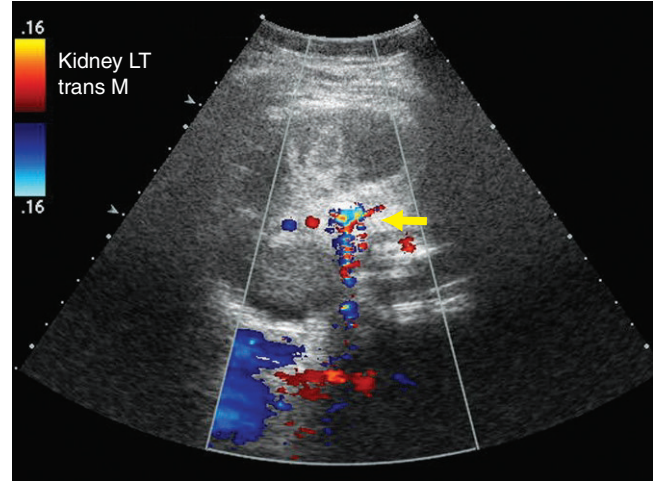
Color Doppler ultrasound demonstrated the kidney with fairly avascular but with focal echogenicity having ring-down artifact (arrow) posterior to the echogenic stone.
